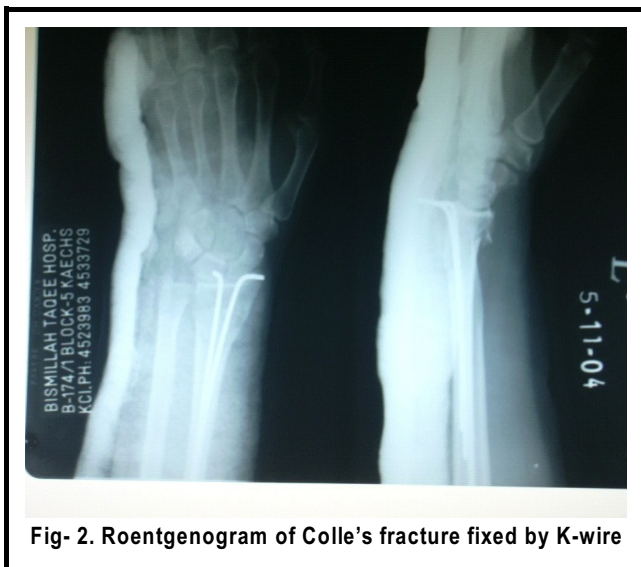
Roentgenogram of Colle's fracture fixed by K-wire
